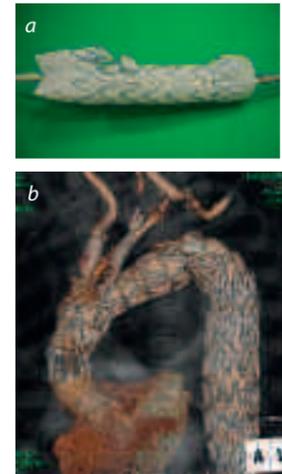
Cook Medical Internal/External Branch Graft for the Aortic Arch. (a) Bench view of Internal/ External Branch Graft. (b) CT after deployment in a patient with branch grafts in the innominate and left common carotid arteries (Images courtesy of Dr T Chuter).
